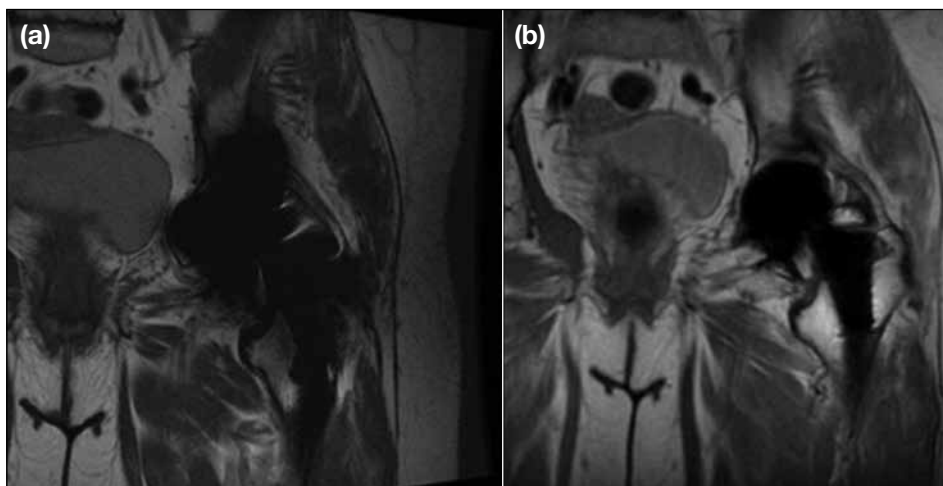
Coronal T1-weighted images of the hip using (a) two-dimensional fast spin echo with basic metal artefact reduction techniques, and (b) the multi-acquisition variable resonance image combination technique that results in noticeable artefact reduction (images courtesy of GE).
